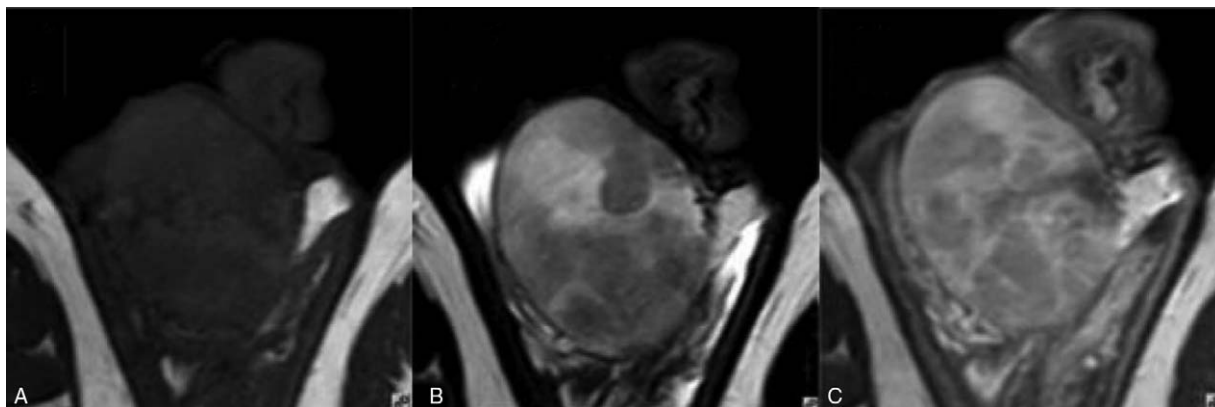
Thirty-three-year-old male with seminoma of the right testicle. (A) Transverse T1WI showing right testicular enlargement and an isointense signal; (B) transverse T2WI showing the tumor was formed by multiple hypointense nodules with isointense tissue between the nodules; and (C) transverse T1WI+CE showing the slim fibrous septa between the nodules was enhanced to the same extent as the internodal tissue. CE=contrast enhancement, T1WI=T1-weighted imaging, T2WI=T2-weighted imaging.
